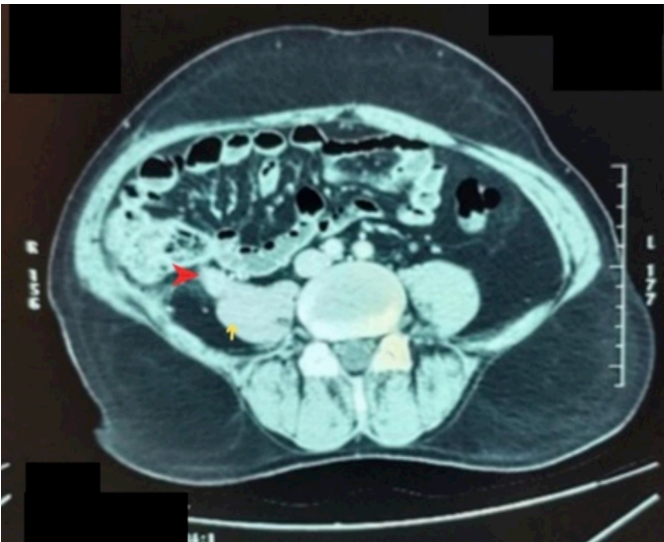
Pre-metastasectomy Contrast-enhanced computed tomography axial view showing renal bed recurrence (red arrowhead). The lesion is well-defined, heterogeneously enhancing in the surgical bed abutting the right psoas muscle (yellow arrow).
